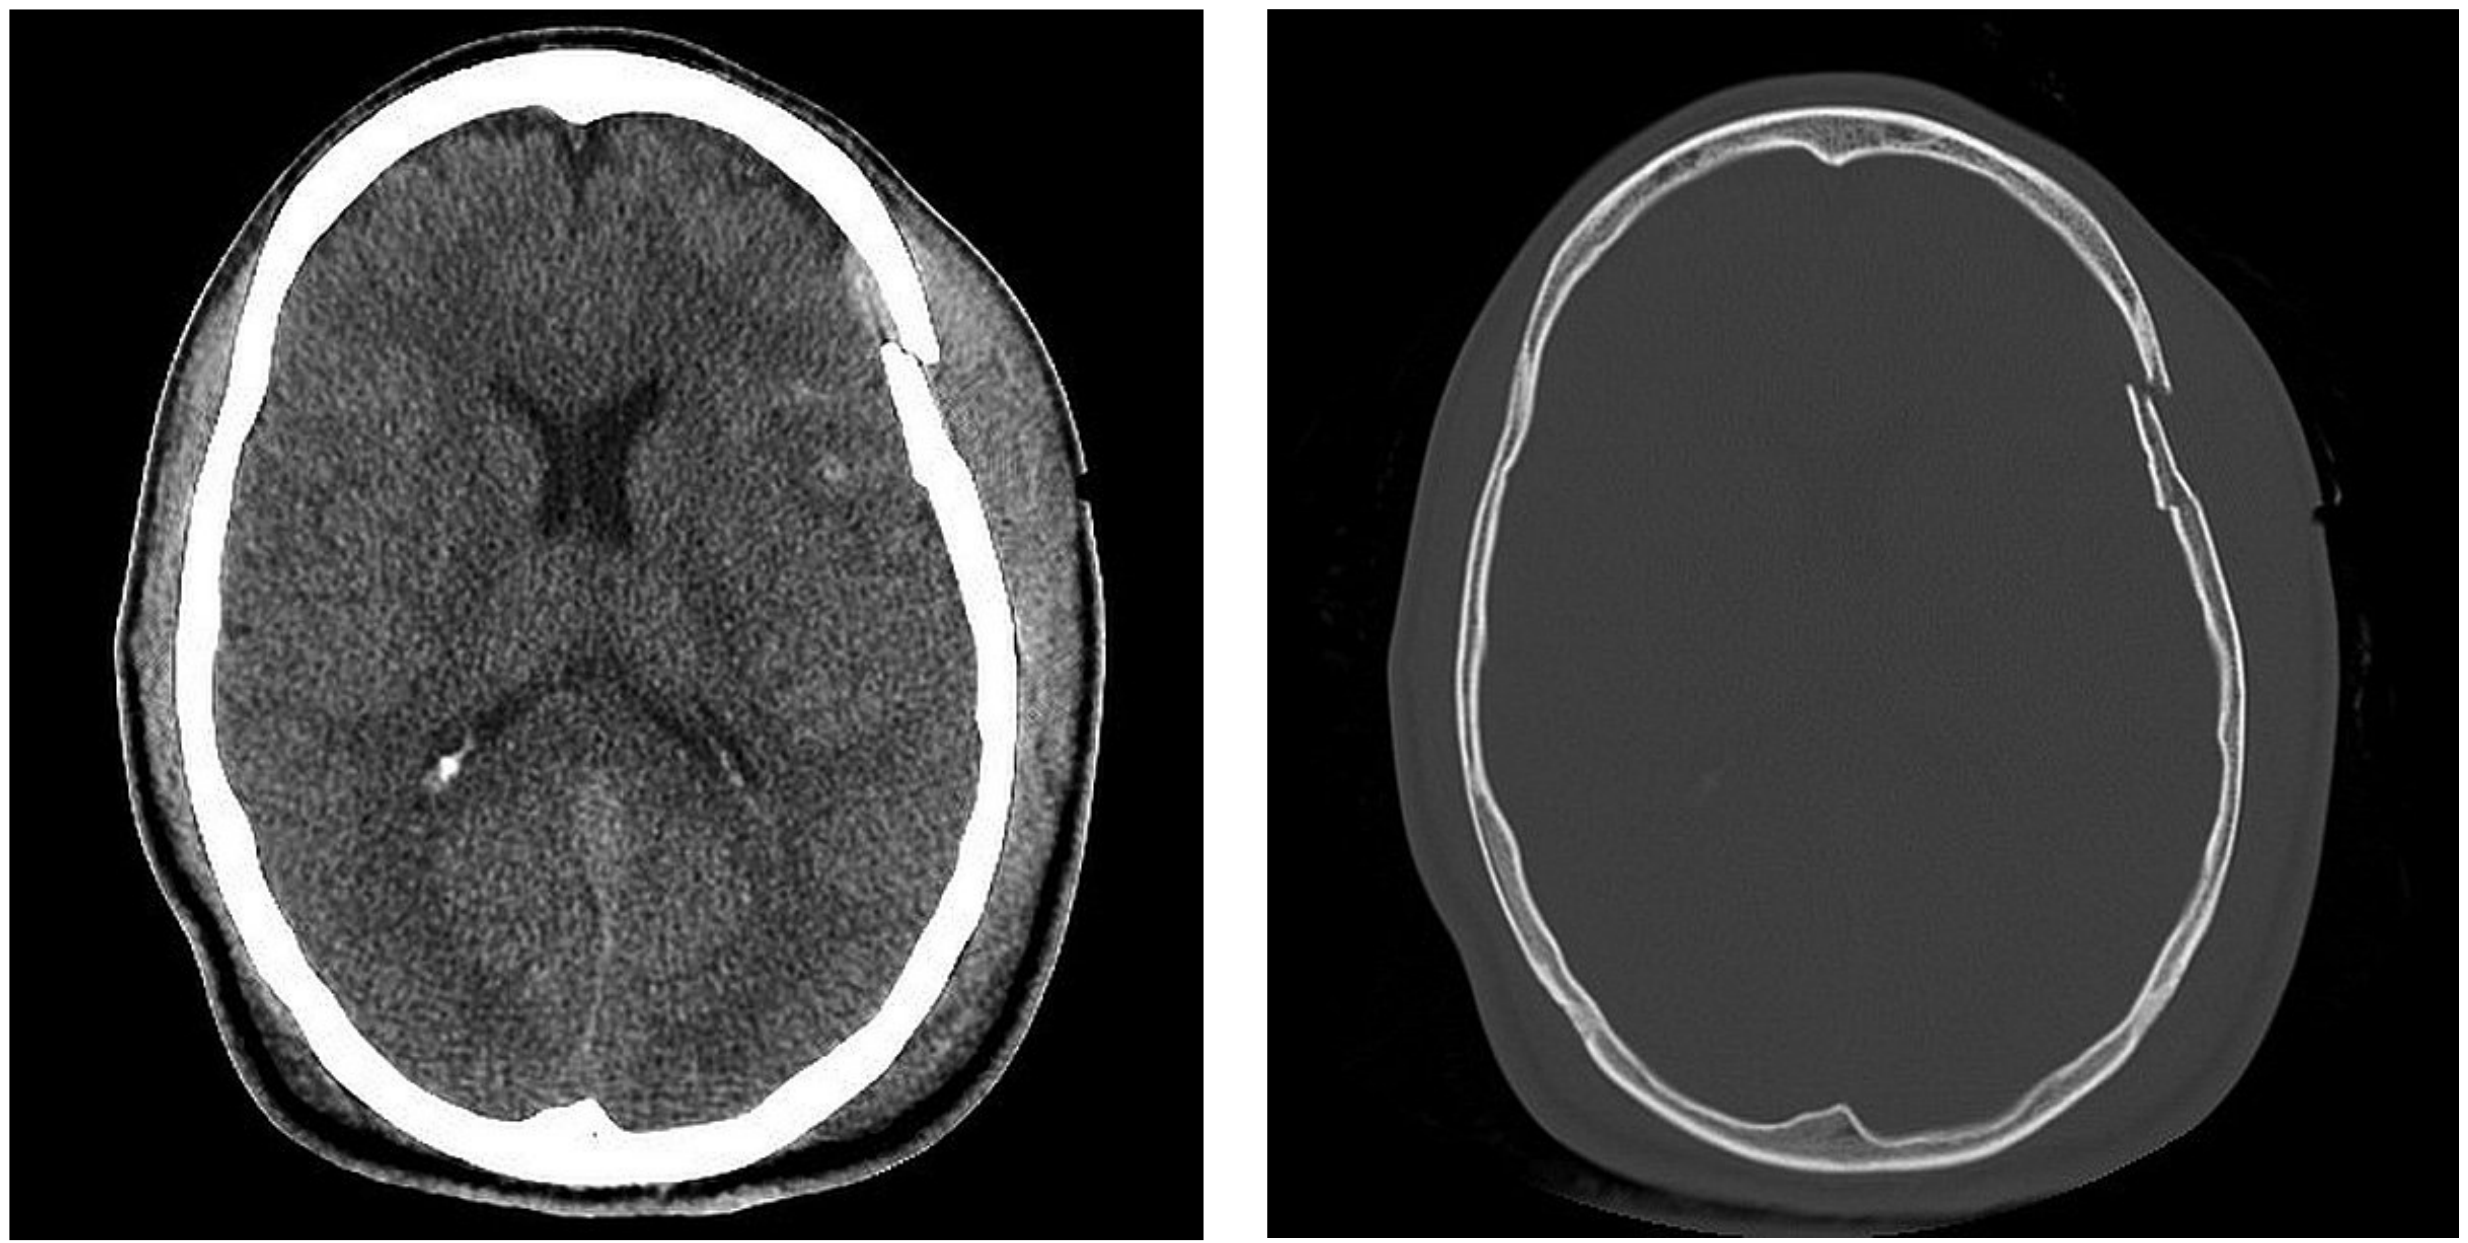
Axial CT (a) brain and (b) bone windows demonstrating a focal comminuted and depressed left frontal skull fracture with associated extra-axial blood and parenchymal contusion.
